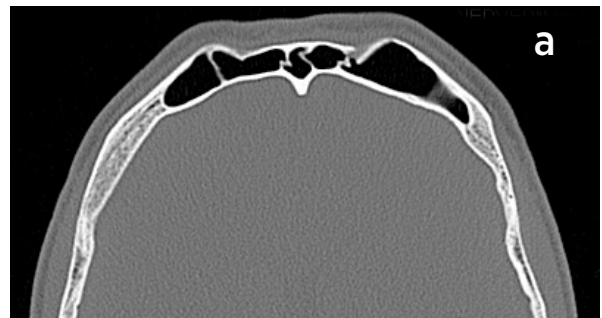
a, b. Computed tomographic scan shows healed impressive fracture of frontal sinus anterior table
